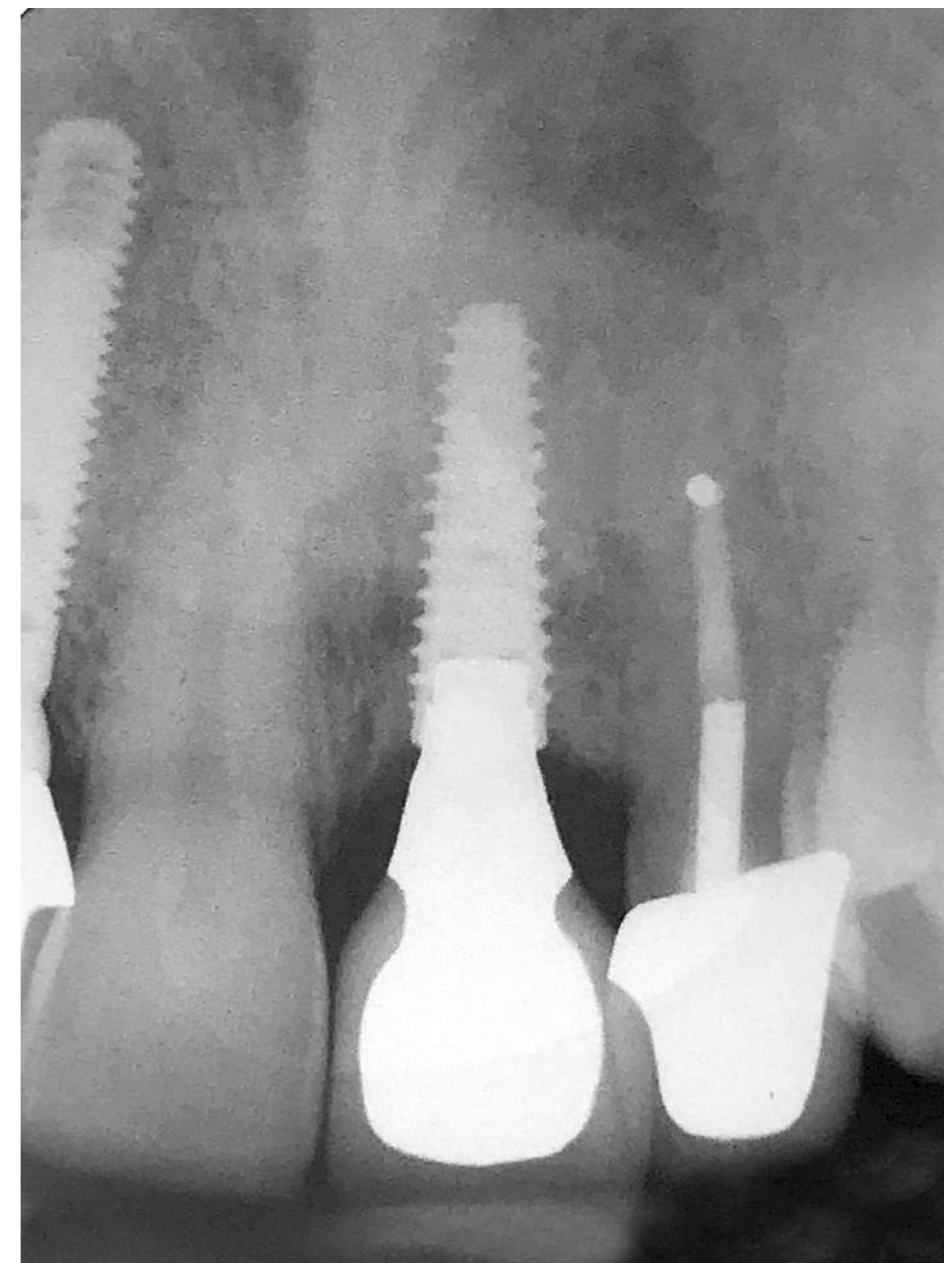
The final periapical radiograph reveals the interproximal levels of bone for the well-integrated implant.
